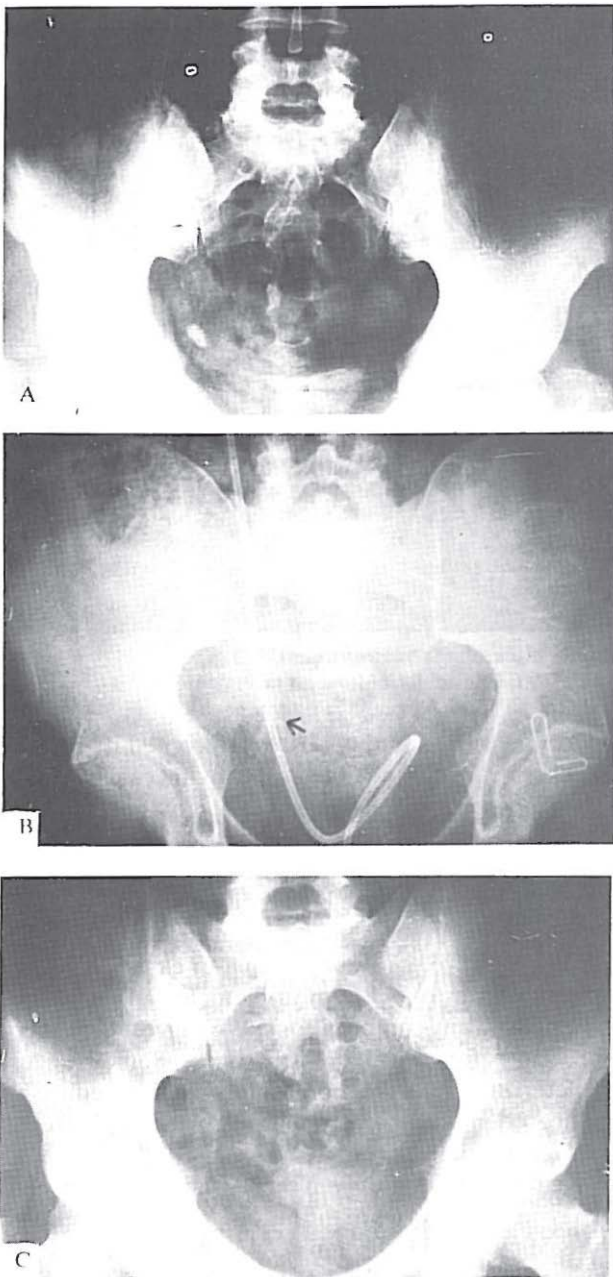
A, right lower ureter stone. B, pelvic radiograph following stone fragmentation (arrow). Ureteral catheter is in place. C, control film one week after TUL with catheter removed and no evidence of stone in ureter.
